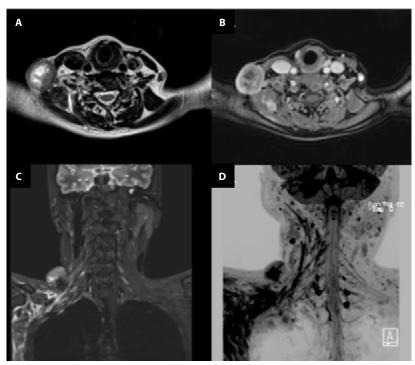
Magnetic resonance images of neck and brachial plexus. Axial sections of T2-weighted sequences (A), post-contrast T1 (B), oblique coronal section T2 SPACE / STIR sequence, coronal section of T2 SPACE / STIR 3D-MIP inverted grayscale sequence (C). A right supraclavicular solid mass is identified with irregular borders and heterogeneity in the T2-weighted sequence, showing a hyperintense center and heterogeneous enhancement after intravenous contrast administration, with central necrosis area. It infiltrates the deep tissues and roots of the brachial plexus. Brachial plexus trunks and fascicles show nodular thickening and alterations in signal intensity on T2/STIR sequence, and show enhancement after intravenous contrast administration. In addition, multiple cervical, infraclavicular and axillary adenopathies are observed on the right side (A-D). These findings are associated with atrophy and diffuse hyperintensity of the trapezius, scalene, as well as supraspinatus and infraspinatus muscles on the right side, with enhancement in relation to denervation (not shown)
